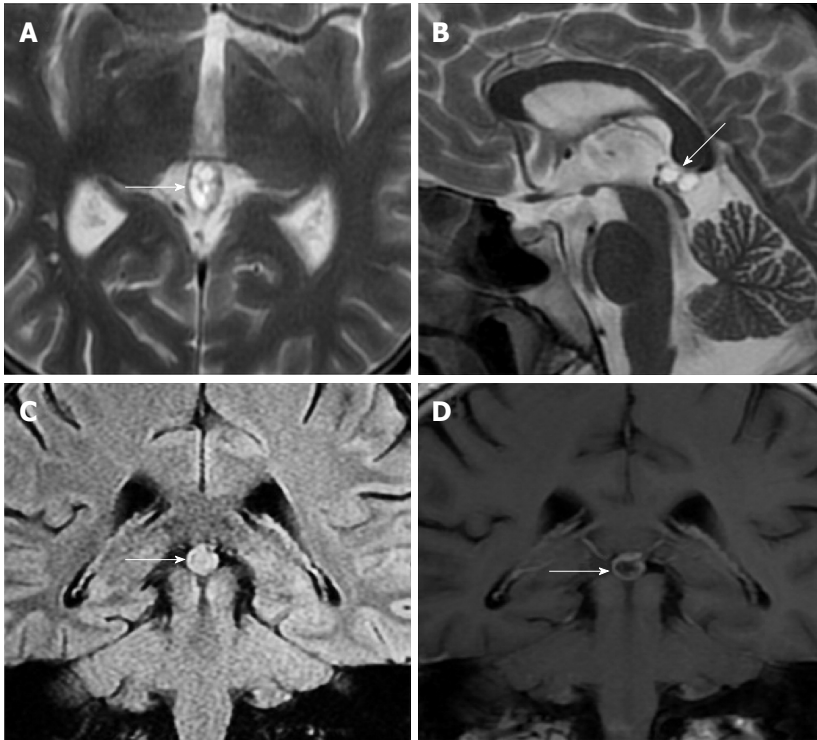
Fifty years old male patient with atypical pineal cyst (patient No. 40). Axial plane (A) sagittal plane T1 weighted (B) axial plane (C) sagittal plane contrast-enhanced magnetic resonance imaging (D). A, B, C and D: Bilocular, lobule contoured atypical pineal cyst is shown in pineal area (white arrows); C and D: Partial rim-like enhancement is shown (white arrows).
